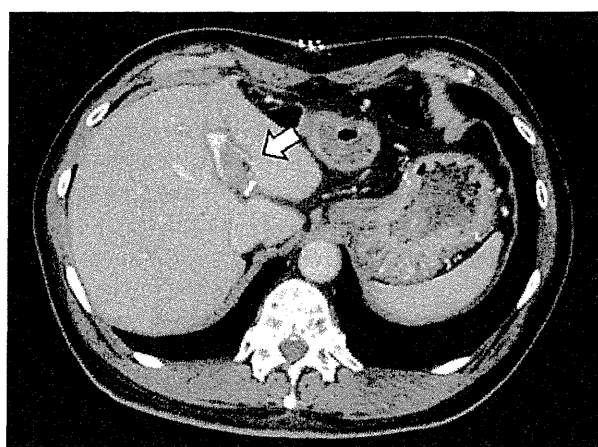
CT on day 6 revealed a portal thrombus in the umbilical portion close to the PDV stump (white arrow)
